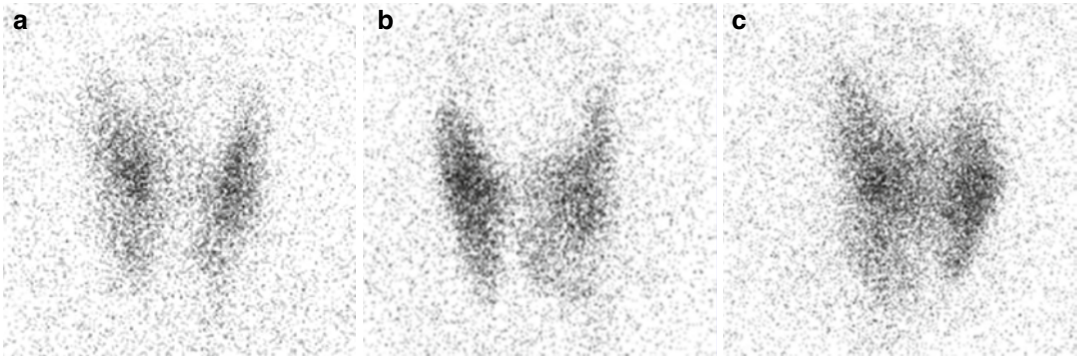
Thyroid scintigraphy of subacute thyroiditis. A 14-year-old girl with sweating and hot flashes was found to have a suppressed TSH (0.2 mU/l) and elevated total T4 level (14.7 mcg/dl). There was no thyroid tenderness. After administration of ^{123}I , radioiodine uptake was 5 % at 4 h and 3 % at 24 h. Scintigraphy performed with pinhole images of the thyroid gland
